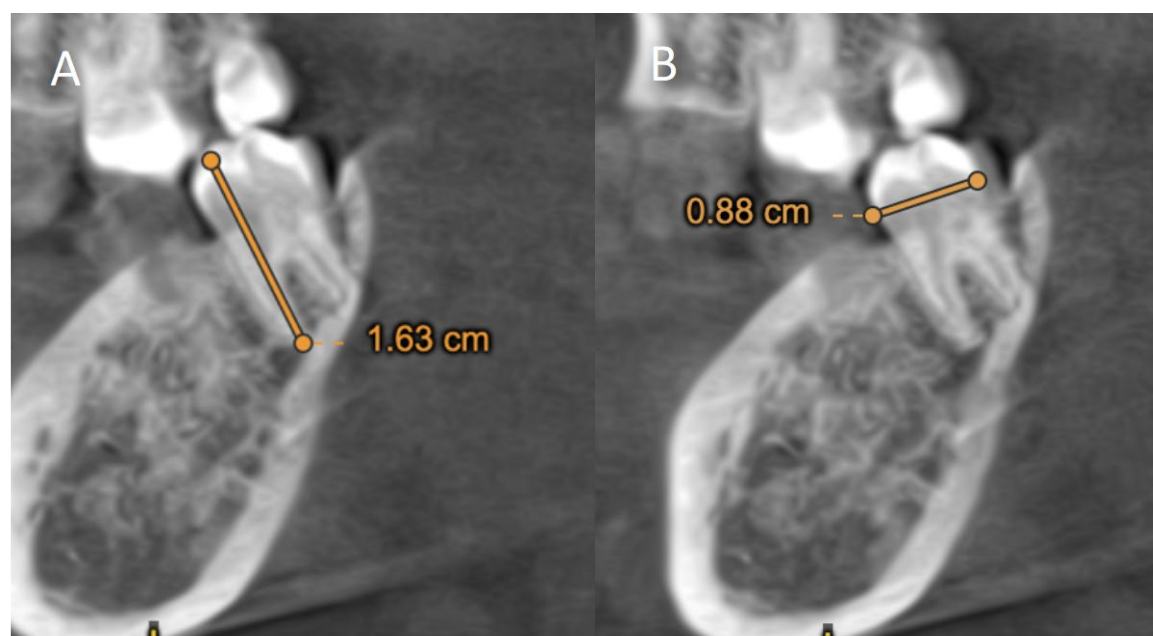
Cone Beam Computed Tomography (CBCT) of 48 tooth (preoperative). (A)Height of tooth 48 from mesial cusp to mesial root (B)Crown width.
